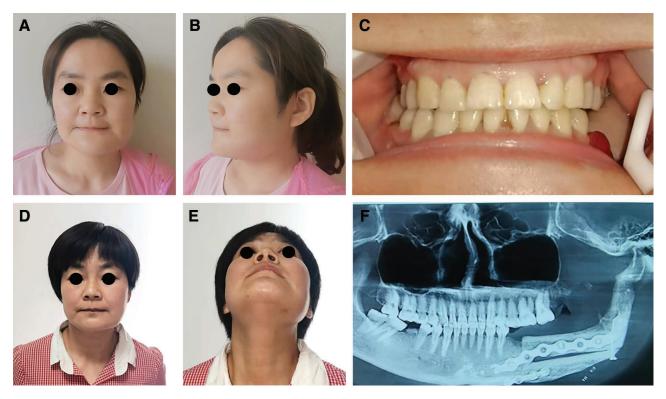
Postoperative outcomes of intraoral reconstruction of the hemimandible. Frontal and lateral views of the patient at 2 weeks (A, B) and 17 months (D, E) after surgery showing no obvious scar and a relatively symmetrical facial contour. Postoperative images at 17 months showing a tiny scar on the submandibular region due to the placement of a drainage tube. C, Postoperative dentition occlusion at 2 weeks. F, Postoperative CBCT scan at 1 year, showing continuity of the jaw, adequate position of the condylar head, as well as bone healing at the junction of the transplanted flap and the residual mandible.
